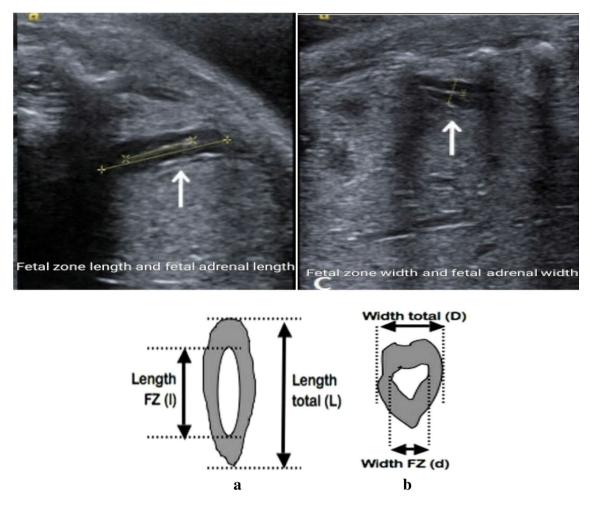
Ultrasound image of fetal adrenal gland showing different measurement. a Fetal zone & adrenal gland lengths measurement, b Fetal zone and adrenal gland widths measurement
